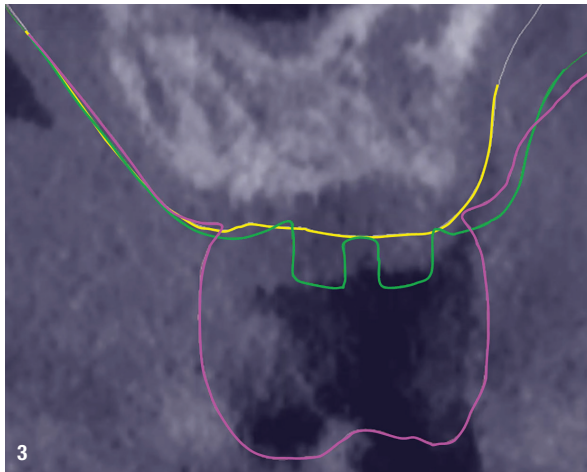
Standard superimposition of the intra-oral scans taken before surgery (yellow line), at soft-tissue healing (green line) and at prosthesis delivery (purple line) on the pre-op CBCT scan (the right side is the buccal side).
